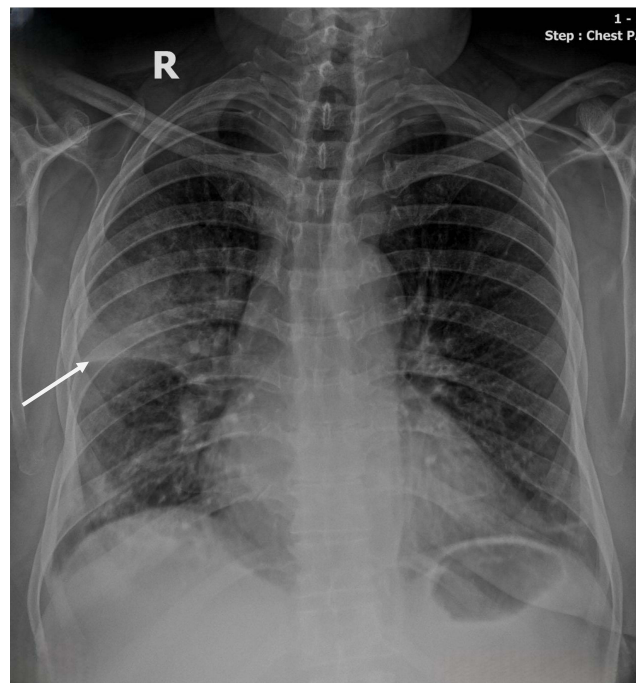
Chest x-ray demonstrates pneumonia. The arrow indicates the right upper lobe consolidation.
